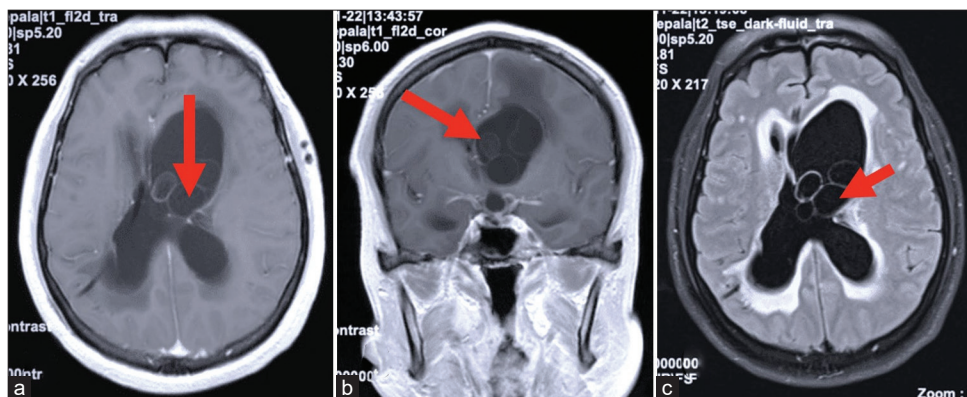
The magnetic resonance imaging reveals multiple masses located within both lateral ventricles (red arrow). (a and b) Contrast-enhanced (a) axial and (b) coronal T1-weighted images. (c) Fluid-attenuated inversion recovery image showing similar intensity between the mass and cerebrospinal fluid.
